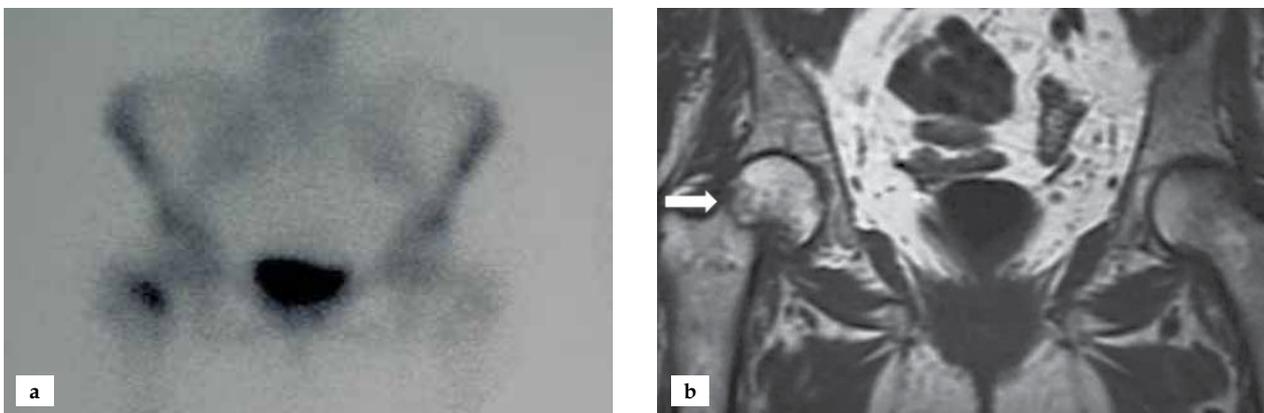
Stress fracture of right femoral neck of a young athlete with no obvious findings a. An increased concentration of radioisotope during bone scanning b. MRI shows the fracture (arrow)
